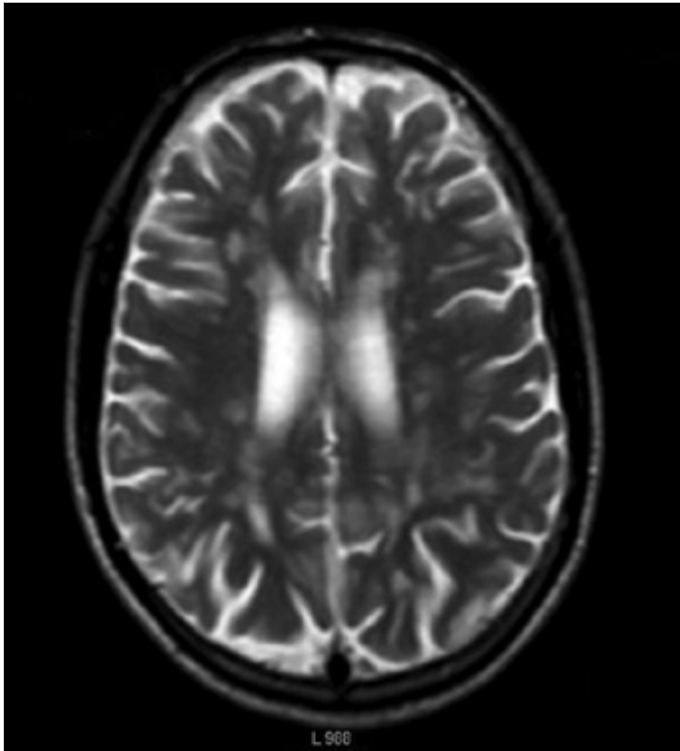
Axial T2-weighted image showing multiple hyperintense foci in the periventricular area, which are consistent with MS plaques
